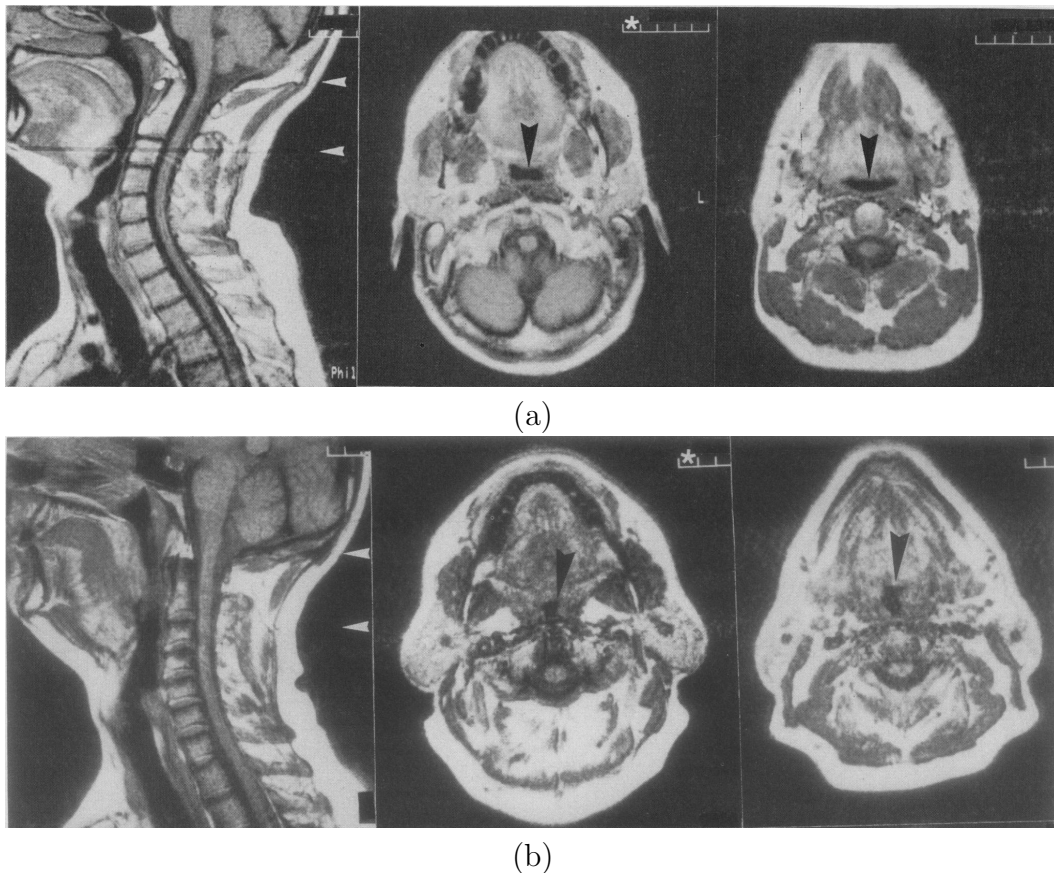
MRI scans, courtesy of Rodenstein *et al.* (1990), showing the sagittal slice on the left image and two transverse slices taken at the heights indicated by the white arrows (middle image at top arrow and right image at bottom arrow) corresponding to (a) A normal subject and (b) An OSAHS patient
